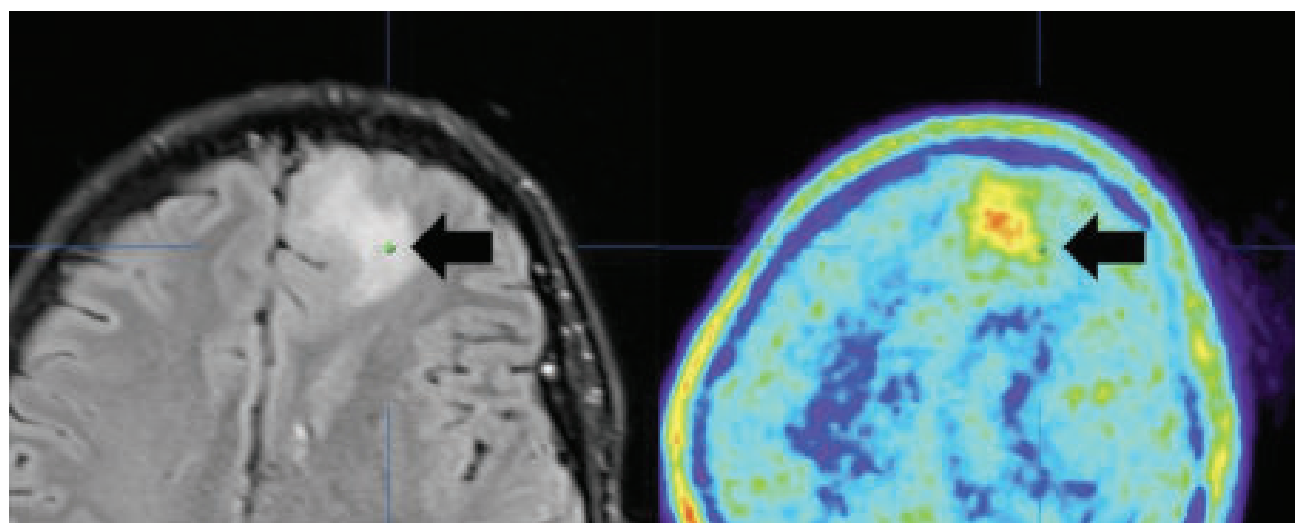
On the left, an image of the brain obtained using magnetic resonance imaging; on the right, using a new tyrosine PET procedure. The location of the tumor is indicated by the arrow.
